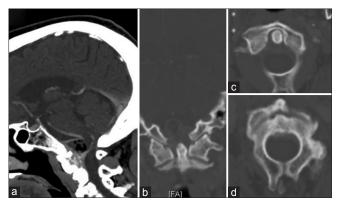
Initial sagittal (a) and coronal (b) computed tomography scan obtained at presentation demonstrate a non-enhancing mass centered along the posterior aspect of the clivus and C2, eccentric to the right, with soft tissue air. Not associated with erosive bony changes of either the dens (c) or the body of C2 (d)
